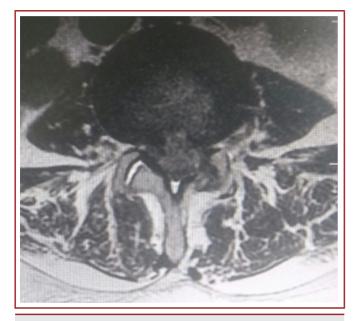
Preoperative sagittal MRI axial image
